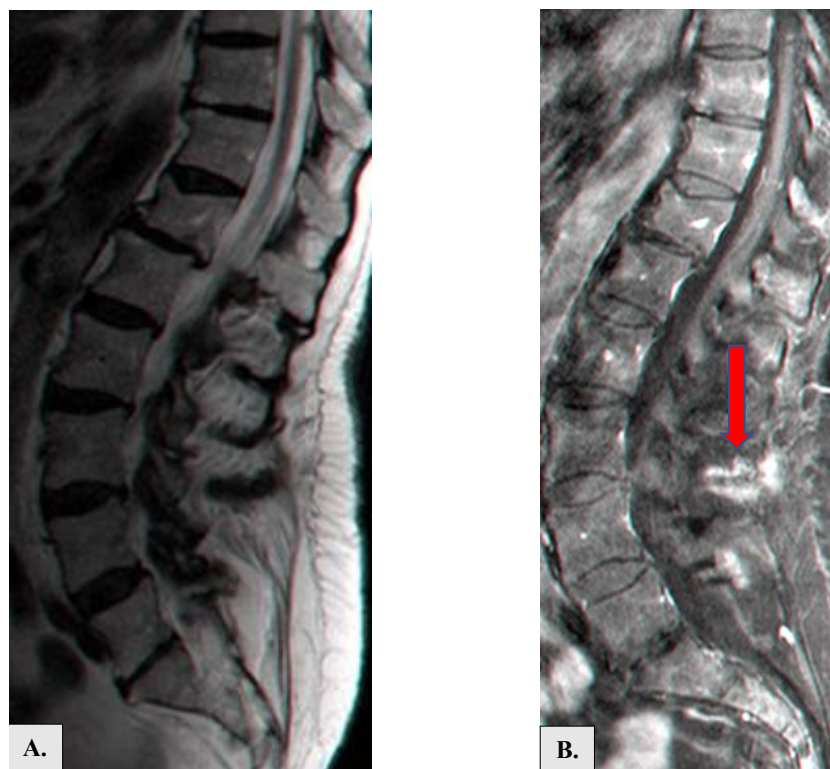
A): MRI sag. T2 and Fat / Sat after contrast medium. B): after administration of contrast medium, impregnation is evident from the local inflammatory state of the interspinous ligament L3-L 4 (arrow).*
